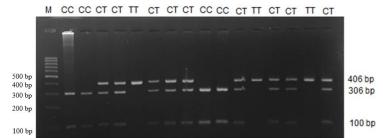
PCR-RFLP results of the *CFHR5*[*Acil* genotyping on 1.5% agarose gel. M : DNA marker 100 bp; CC,CT, and TT are genotypes.
